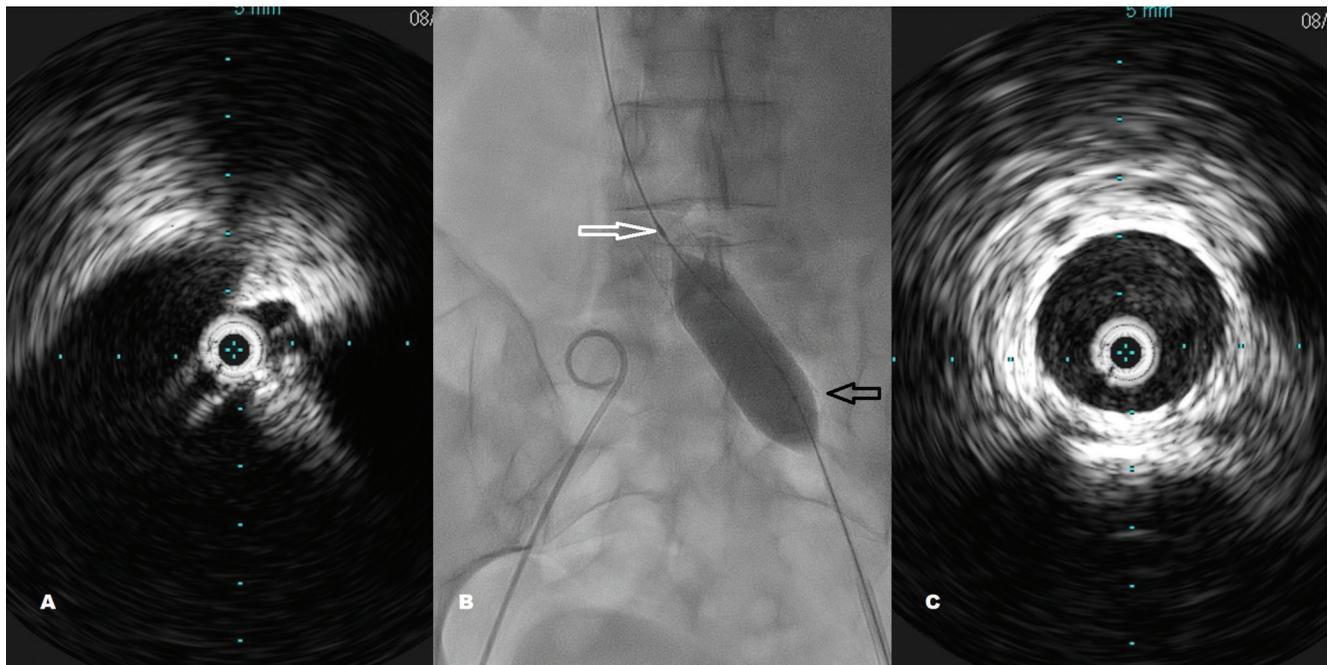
[A] Iliac compression as seen on intravascular ultrasound. [B] Post-stent dilation with Atlas Gold balloon. White arrow = tapered tip that prevents balloon from sticking on stents; black arrow = short and tapered shoulders on balloon that prevent dilation outside stent. [C] Post-dilation intravascular ultrasound showing a well-apposed and expanded stent.
